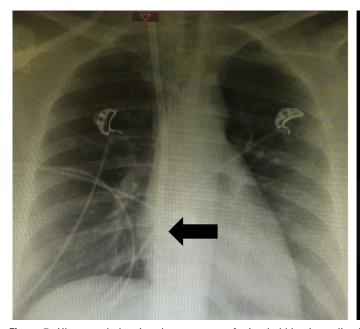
(a) Bedside chest radiography showing the inadequate positioning of the hemodialysis catheter in the right atrium (black arrow) after catheter insertion in the right internal jugular vein. (b) Ultrasound subxiphoid view showing right atrium (RA) and ventricle (RV) before the administration of microbubbles through the distal lumen of the catheter. (c) Ultrasound subxiphoid view showing the absence of microbubbles in RA and RV 4 seconds after their flush through the distal lumen of the catheter. Dynamic views can be visualized in Figure 7.
